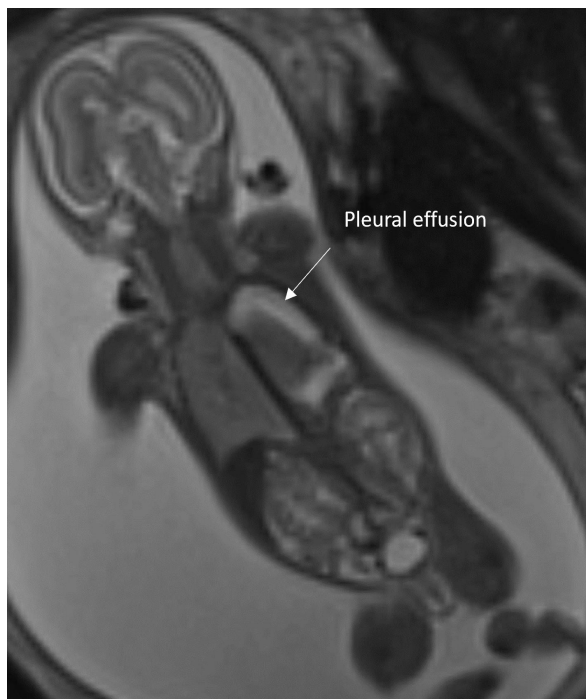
T2 HASTE Coronal MRI image of pleural effusion in 20+4 week fetus
